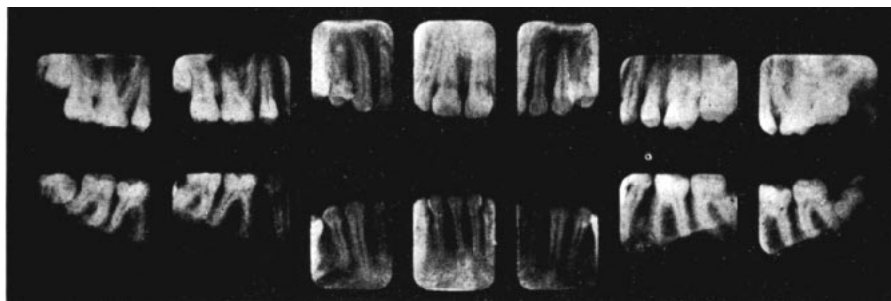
Radiographs of Case II after completion of active treatment.
